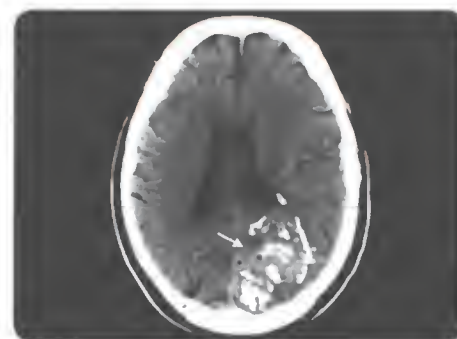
Axial section of computed tomography scan showing left occipital arteriovenous malformation (AVM) (arrow)
